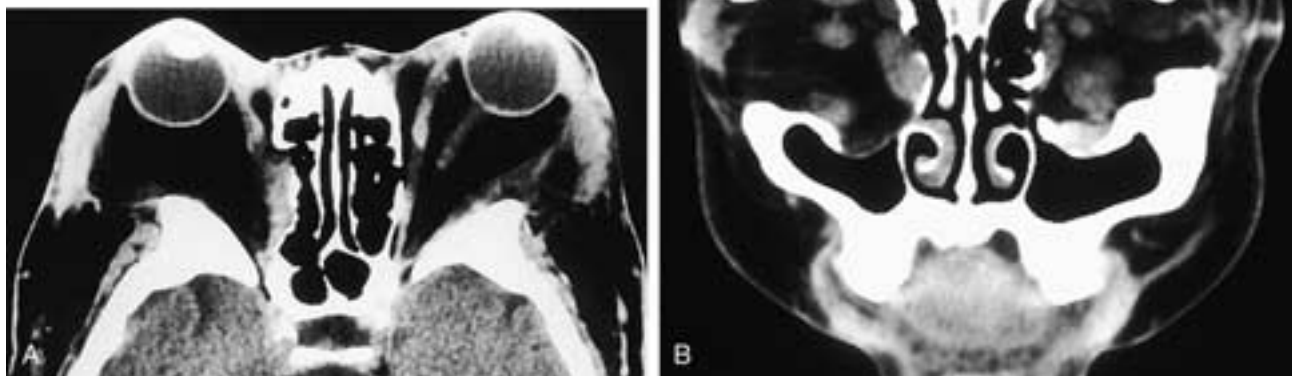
Axial (A) and coronal (B) CT scans show a patient with bilateral thyroid ophthalmopathy and bilateral Krönlein's and orbital floor decompression procedures. A medial right ethmoid decompression was also performed.
